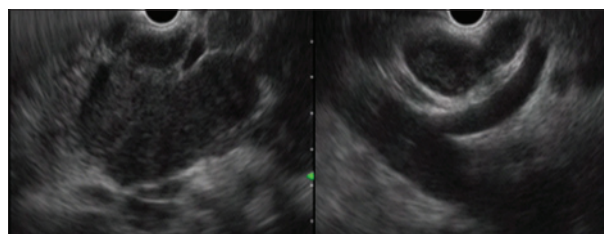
Endoscopic ultrasound: Mass of the head of pancreas (Left). Celiac axis lymph nodes (Right)
